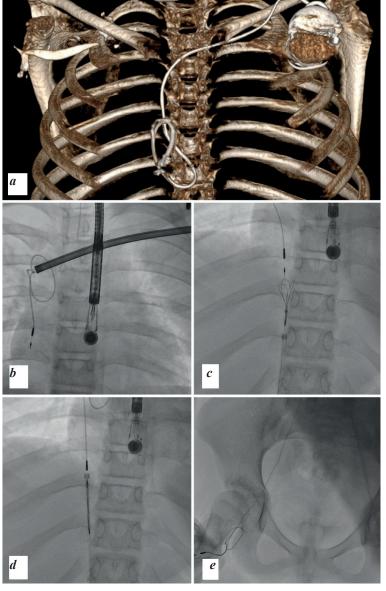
Stages of treatment of an 11-year-old girl: a - multispiral computed tomography of the heart (the electrode is located in the right atrium, coiled with a loop), b - attempted TREE with TightRail 9Fr device, c-e - attempted TREE by femoral access with a three-loop trap.
